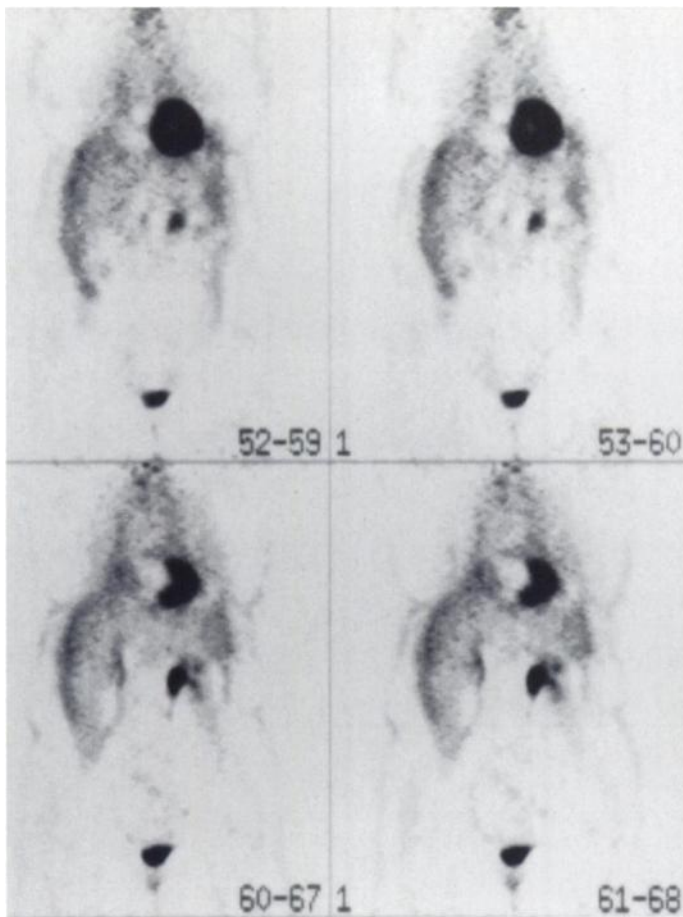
Coronal images of a whole-body PET scan with [^{18}F]FDG-PET shows no evidence of disease 11 mo after the initial therapy with radiolabeled anti-CEA antibodies. The images proceed from left to right, starting from the anterior to the posterior part of the body.
